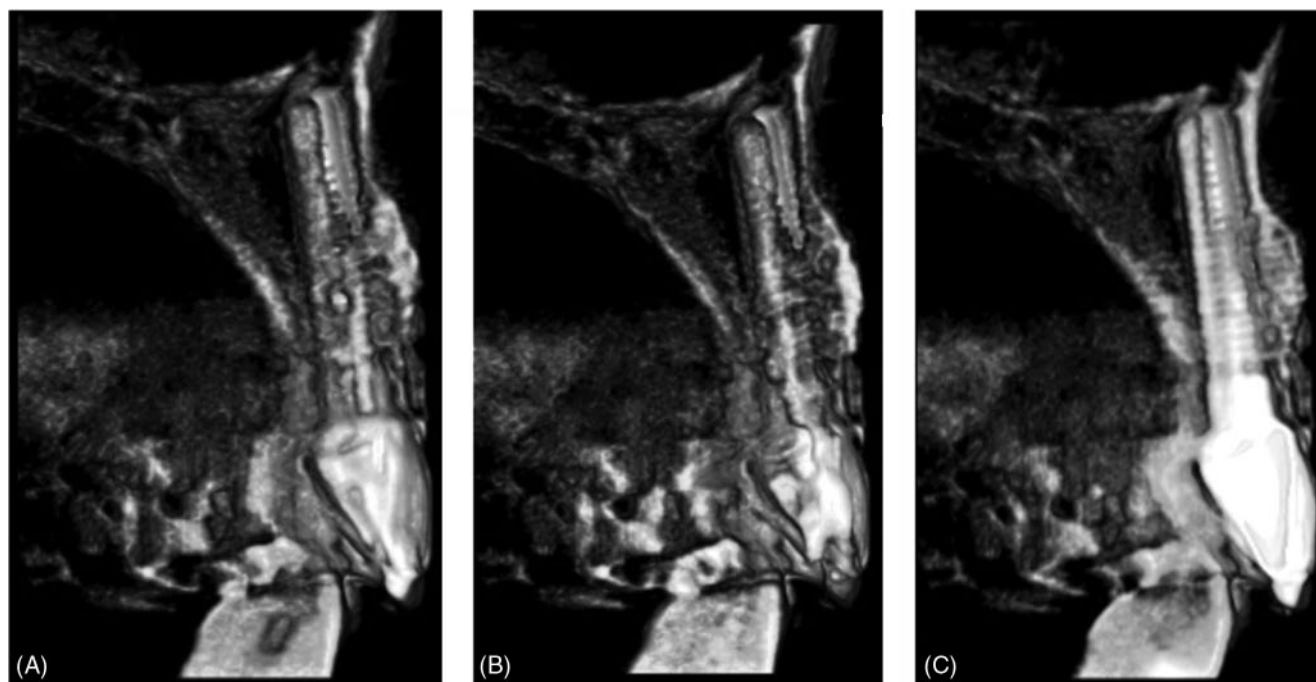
CBCT capturing an implant placed 8 years earlier: (A–C) three consecutive cross-sectional images separated by 1 mm. The residual horizontal defect had been grafted at the time of implant placement with a structurally stable xenograft product (Bio-Oss, Geistlich). This has predictably maintained the facial ridge contour.
